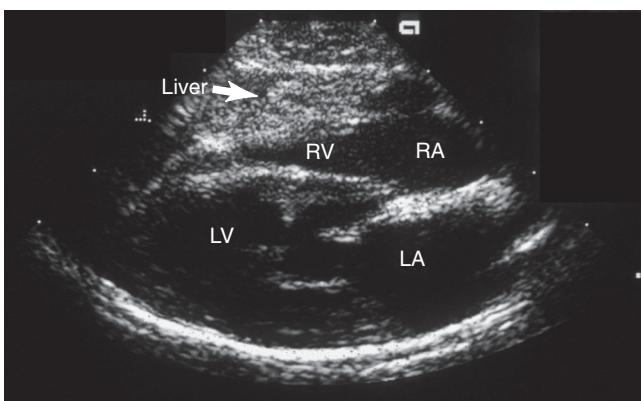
Echocardiographic right-parasternal long-axis image demonstrating the intraperitoneal presence of liver tissue secondary to a peritoneopericardial diaphragmatic hernia.
